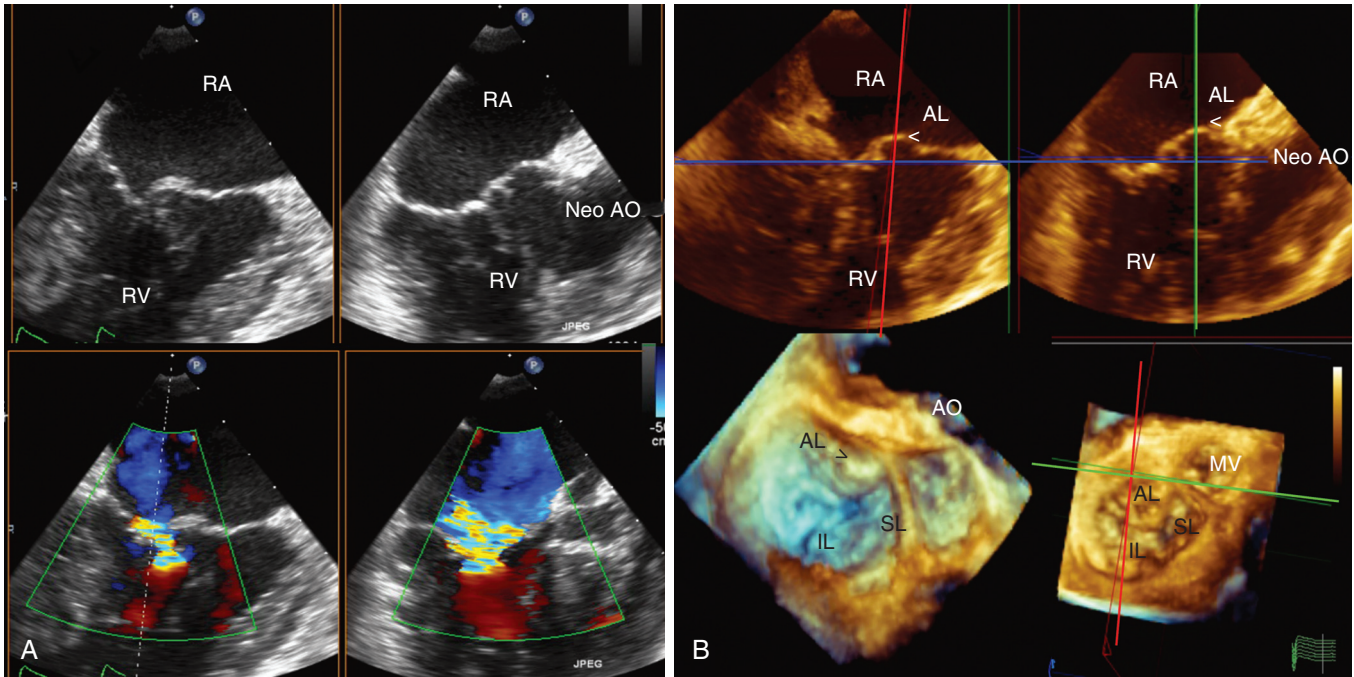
Three-dimensional tricuspid valve after a Fontan procedure. The TEE image labeled A demonstrates moderate tricuspid valve regurgitation after a Fontan procedure in a patient with hypoplastic left heart syndrome and dextrocardia. Although the moderate regurgitation is evident from the color Doppler signal, the precise mechanism and location are unclear. The real-time three-dimensional echocardiographic image labeled B displays the tricuspid valve in the multiplane reformatting mode, as well as a surgical en face view of the tricuspid valve. The *red* and *green* lines are at right angles to each other and show that the main problem is prolapse of the anterior leaflet of the tricuspid valve. The *lower right* image is in the exact spatial location as the upper two images, whereas the *lower left* image has been angled to show the prolapse in more detail. Although not seen from the surgical en face view, the position of the aorta has been noted to help in orientation. AL = anterior leaflet; AO = aorta; IL = inferior leaflet; MV = mitral valve; RA = right atrium; RV = right ventricle; SL = septal leaflet.
